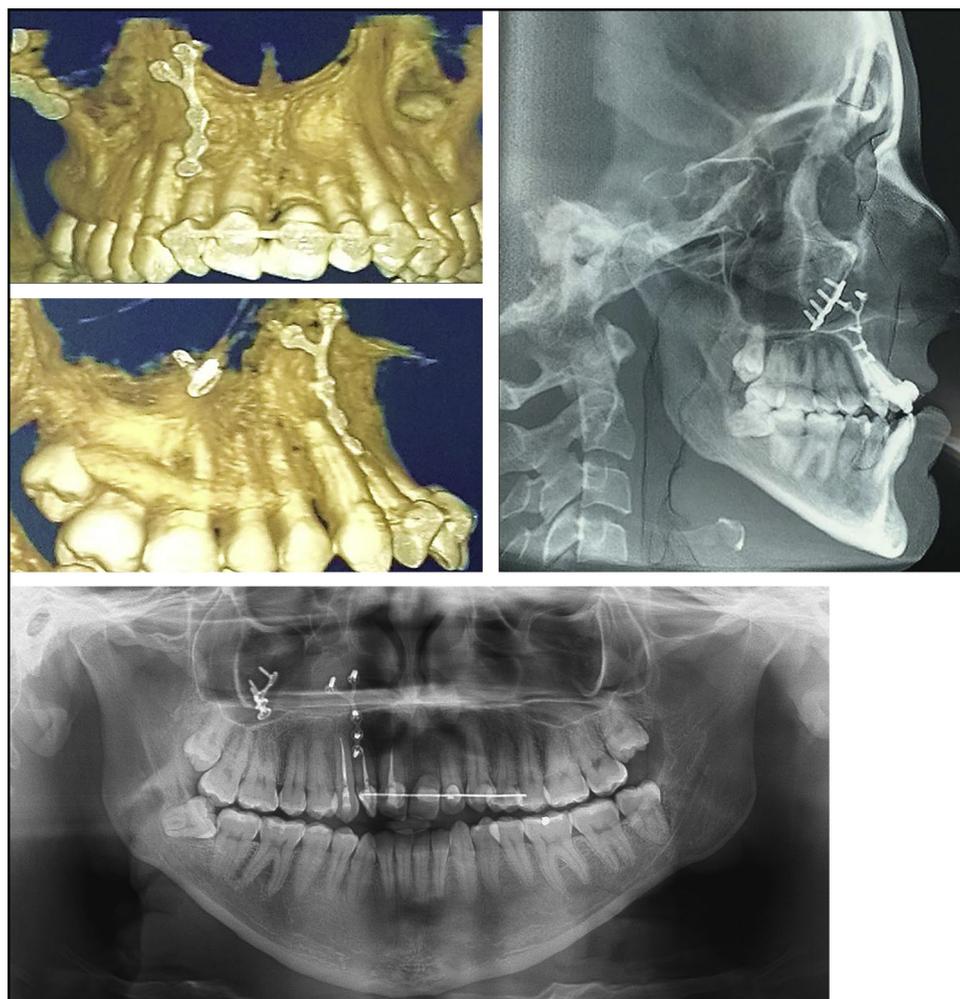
Pretreatment tomography and panoramic and lateral cephalometric radiographs.
